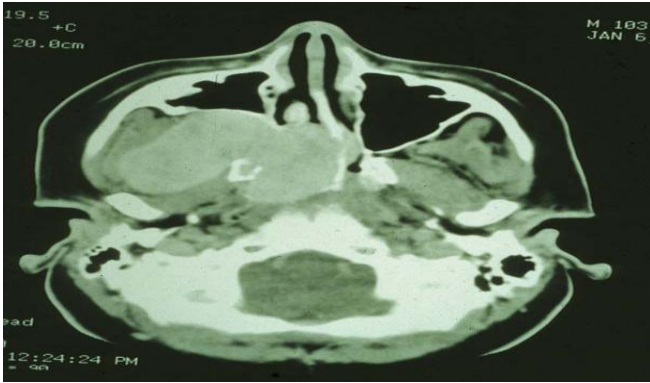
CT Scan of Nose, Nasopharynx, Para Nasal Sinuses and Skull Base Axial View with Contrast showing ISO Dense Mass Involving Right Nasal Cavity, Nasopharynx, Pterygopalatine Fossa and Infratemporal Fossa.
